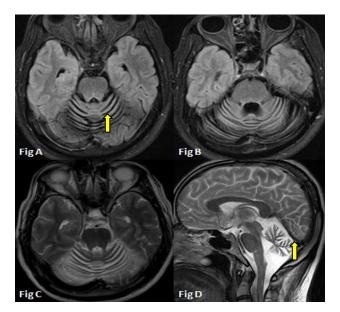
Axial FLAIR and T2WI (Fig A& B) with Sagittal T2WI (Fig D) showed Cerebellar hemispheric atrophy with prominent foliae(Yellow Arrow) and prominent fourth ventricle.
